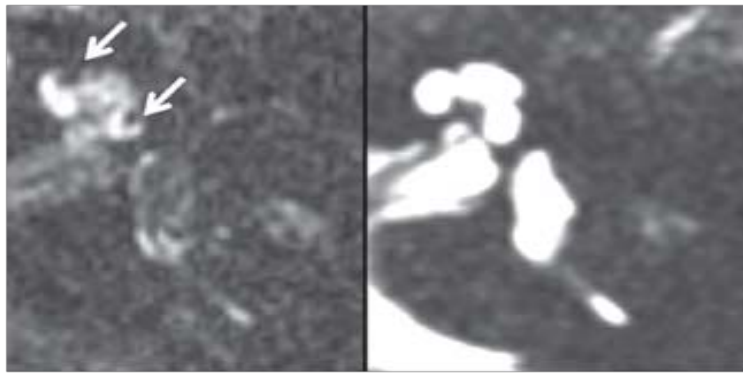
Hydrops-positive cochlea in two dimensional FLAIR sequence (left) and CISS sequence (right). 2D-FLAIR visualizes dilated scala media of basal turn with the white arrows, ELH is visualized by low or no signal intensity region and the perilymphatic space is captured by high signal intensity regions the contrast enhancement [11].
